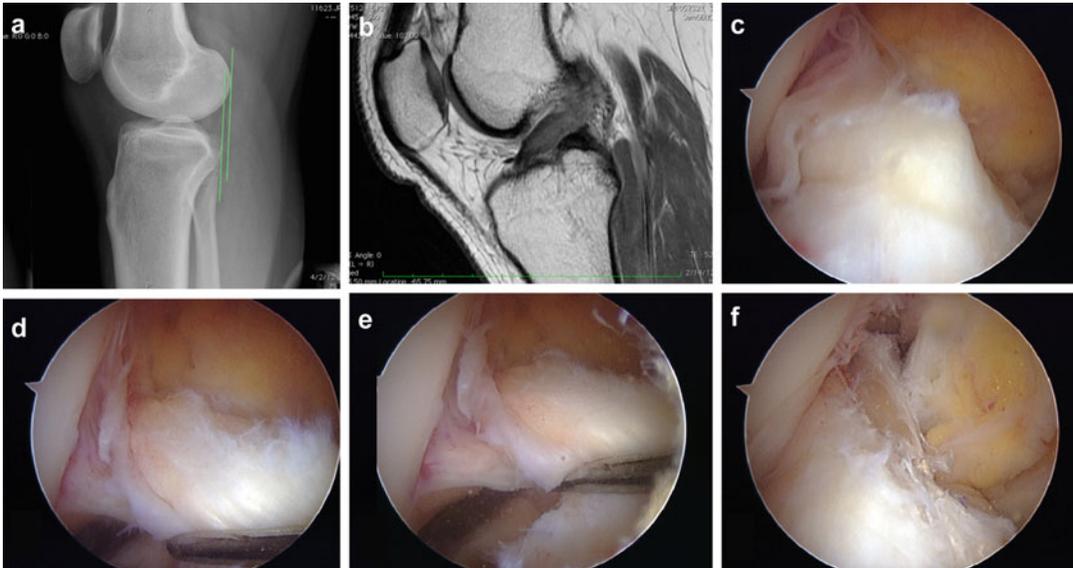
Example of an efficient “PL intact” case where (a) a minor side-to-side difference of 2 mm of anterior tibial translation in Telos™ is recorded; (b) MRI findings show the presence of remaining fibers, but without identifying the type of injury pattern; (c) there are arthroscopic
